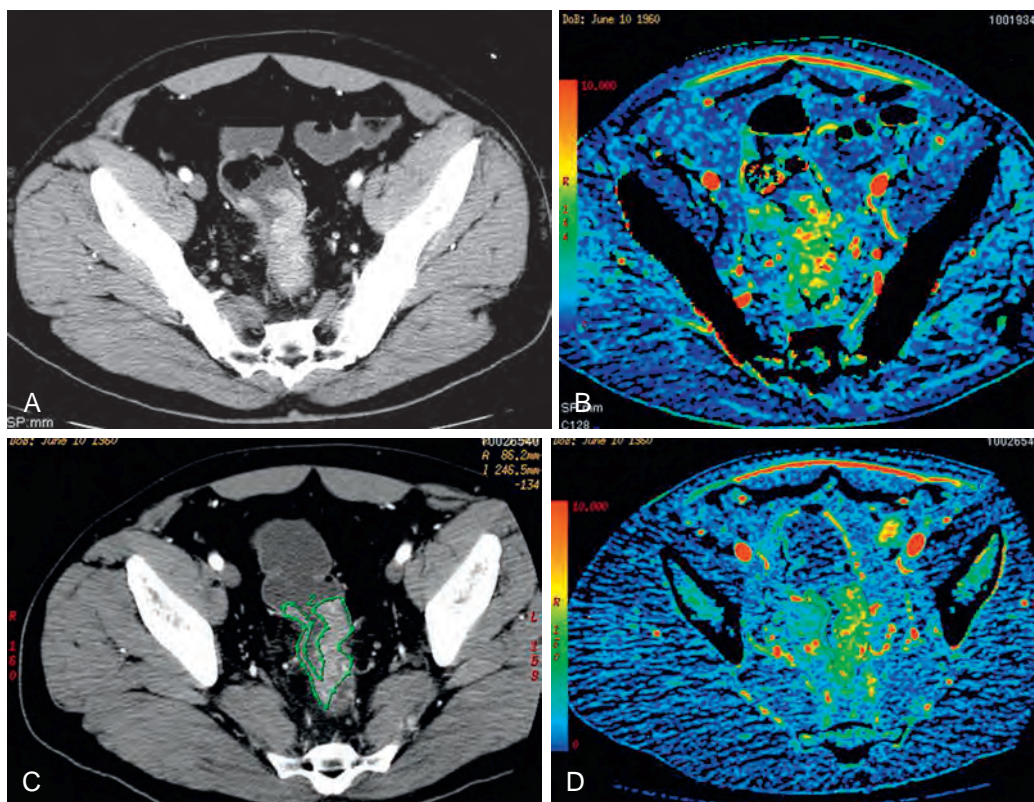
CT perfusion images obtained before and after treatment with antiangiogenic agent in a 72-year-old man with rectal cancer. Axial contrast-enhanced CT image in the dynamic phase (A) shows the avidly enhancing tumor in the rectum; corresponding colored perfusion map (B) demonstrates increased blood flow (78 mL/100 g/min). After treatment with bevacizumab, axial contrast-enhanced CT image (C) shows reduced enhancement; corresponding colored perfusion map (D) demonstrates reduction in the blood flow (20 mL/100 g/min).
